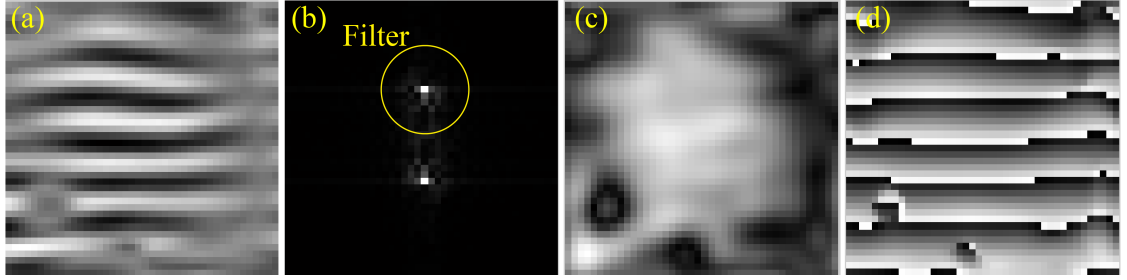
Processing of a tagged MR image. (a) Acquired tagged slice. (b) Harmonic peaks in the Fourier domain and a HARP filter. (c) Harmonic magnitude slice. (d) Harmonic phase slice.
